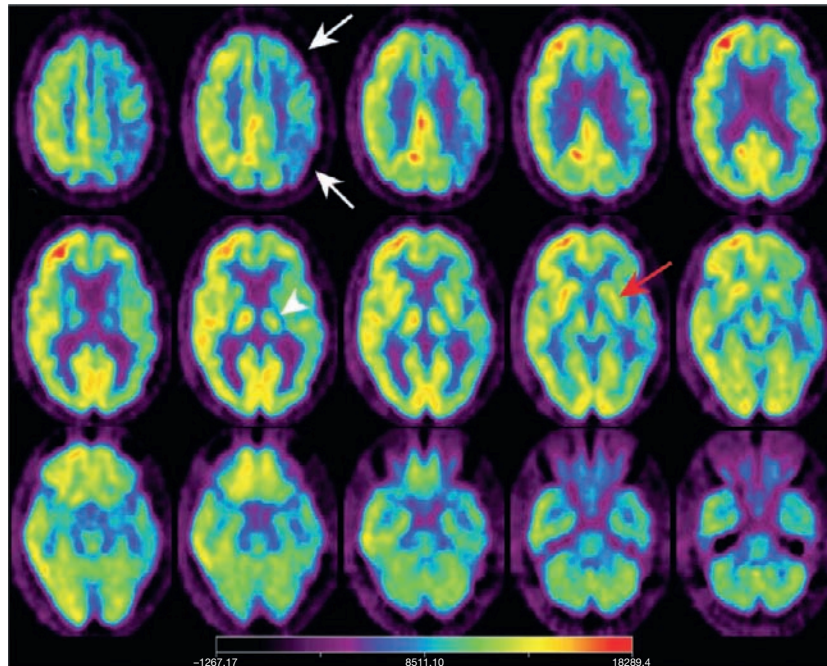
Corticobasal degeneration. Shown are axial sections of an FDG-PET study from a 47-year-old man with progressive agraphia and apraxia, as well as right-sided parkinsonism. Metabolism in the association cortex of the frontal and parietal lobe is decreased (white arrows), as well as in the ipsilateral thalamus (arrowhead) and lenticular nucleus (red arrow).
